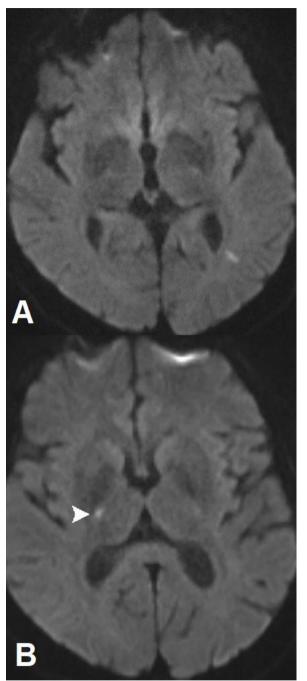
Brain MRI. DWI images show diffusion restriction indicating lacunar infarctions in the left periventricular white matter and the right internal capsule (arrowheads).
